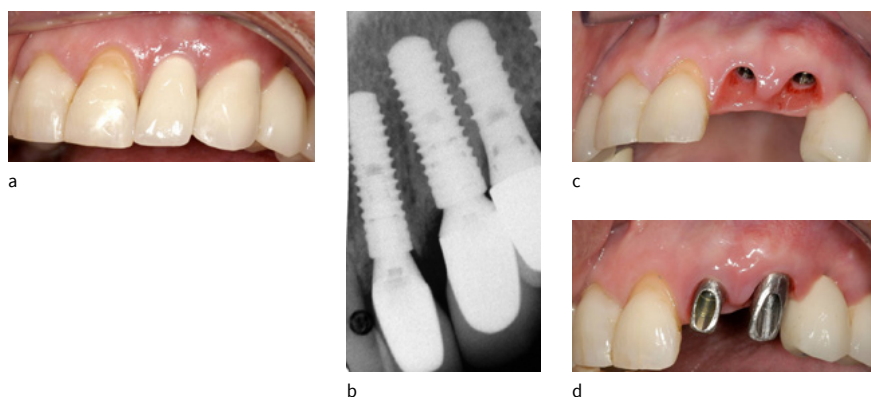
Adjacent platform-switched implants in the esthetic zone. a: Final restorations 2 years post-op show excellent esthetics and tissue stability with full inter-implant papilla. b: Radiograph shows inter-implant bone level at or coronal to implant shoulders. c: Abutments removed showing excellent tissue health. d: Abutments in place showing restorative design for cemented restorations
